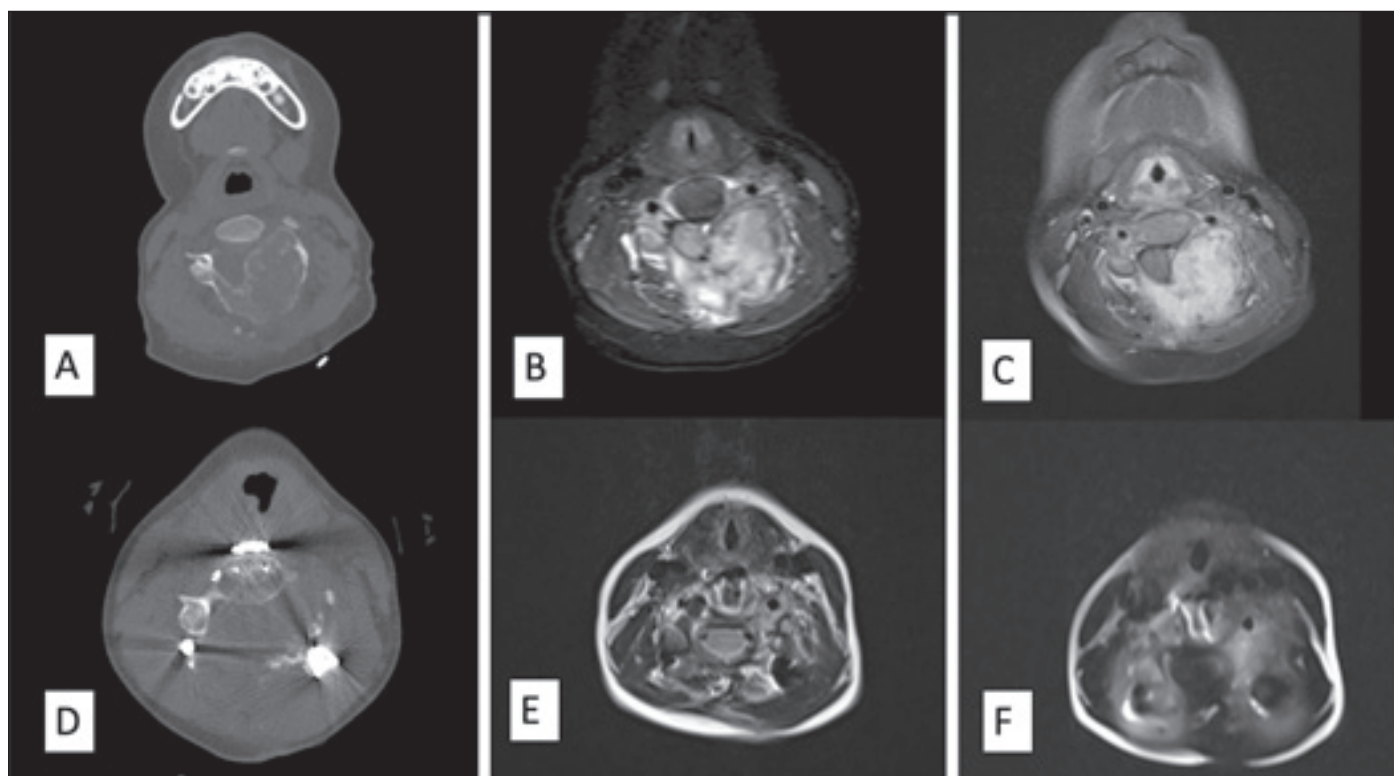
Images of the patient with recurrent osteoblastoma (Patient 11) after recurrence: (A) axial CT image; (B) axial T2-weighted MRI image; (C) axial postcontrast T1-weighted MRI image; (D) postoperative axial CT image; (E) postoperative axial T2-weighted MRI image; (F) postoperative axial postcontrast T1-weighted MRI image.
